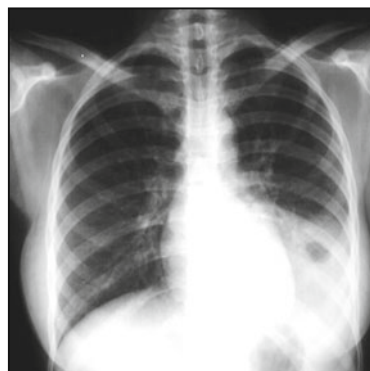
The chest x-ray (PA view) showing shrinking lung volume with bibasilar patchy opacities and a homogeneous opacity in the left lower lobe.
